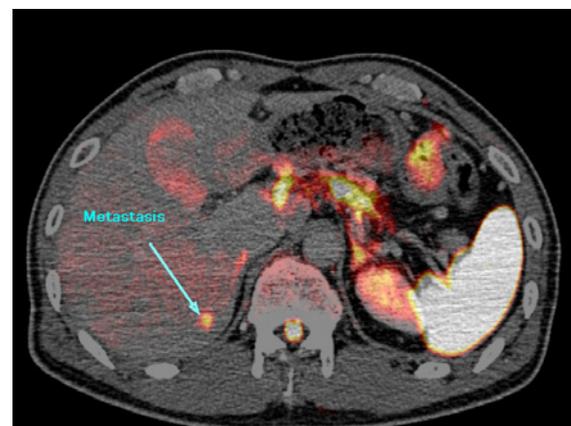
Pancreas carcinoma. Fusion image of enhanced CT and MRI diffusion shows small metastasis in the liver.
